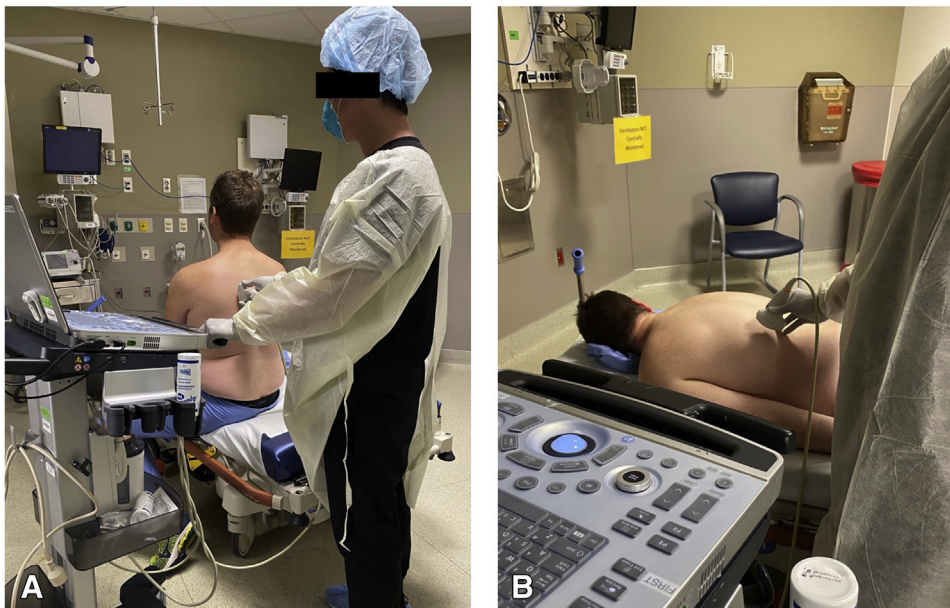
Lung point-of-care ultrasound positioning and image acquisition for scanning patients with suspected coronavirus disease (COVID)-19. (A) In a patient positioned upright, the operator and machine should be positioned behind the patient to minimize exposure risk. (B) Safe positioning can be similarly achieved in a prone patient.
